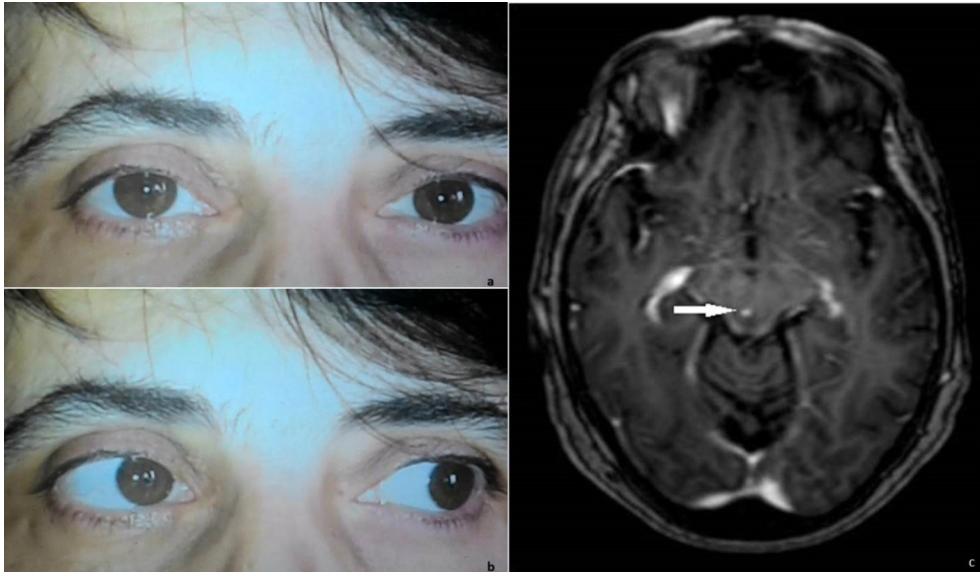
a & b: Right internuclear ophthalmoplegia with decreased adduction of the right eye on attempted left gaze and left-beating jerk nystagmus of the left eye in abduction. c: Magnetic resonance imaging of the brain. T1-weighted sequence after gadolinium-based contrast administration shows a millimetric hyperintense lesion can be visible in the midbrain. These findings are suggestive for sarcoidosis diagnosis with involvement of the central nervous system.
